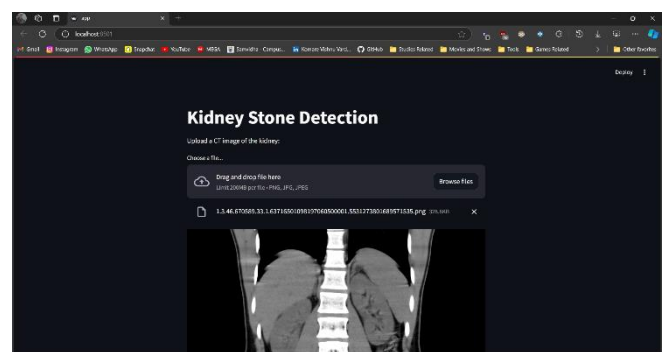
User-friendly webpage interface for KidneyNet-V, allowing healthcare professionals to upload CT images and receive instant predictions for kidney stone detection.
